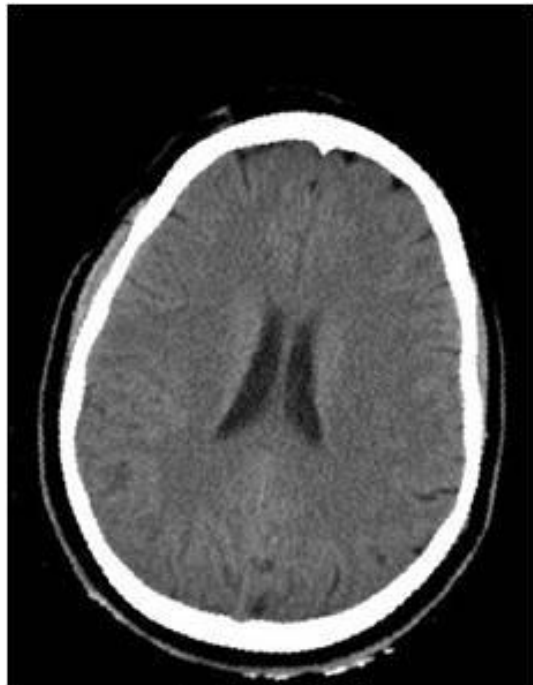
Selected CT slices after the intracranial area detection
